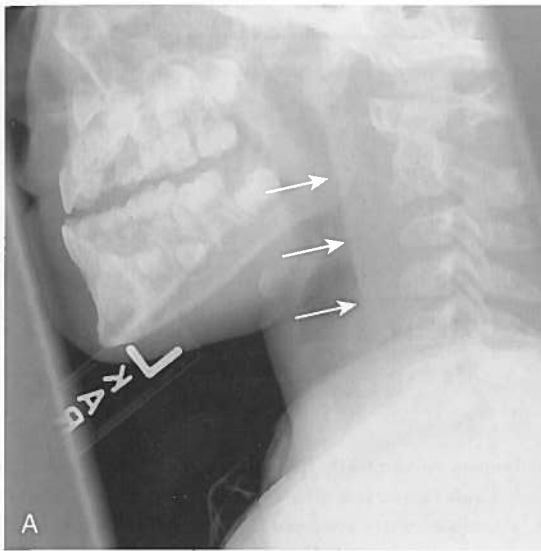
Retropharyngeal abscess. A, Lateral radiograph showing marked thickening of the retropharyngeal soft tissues (arrows), which are wider than the adjacent vertebral bodies. Note the anterior convexity of soft tissues. B, Contrast-enhanced CT shows a low attenuation region with enhancing rim (A), suggestive of a drainable abscess.
